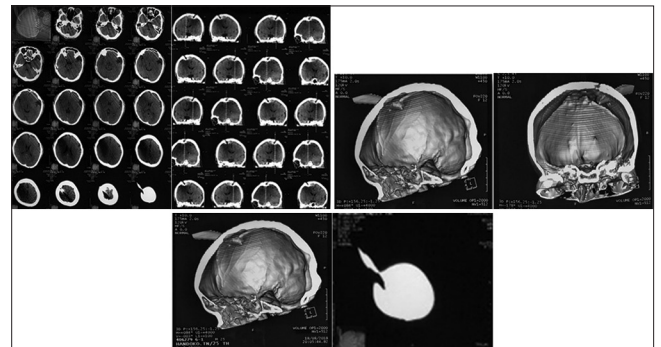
Computed tomography scans on admission, showing that a sickle is located in the right parietal region but no apparent tract hematoma
